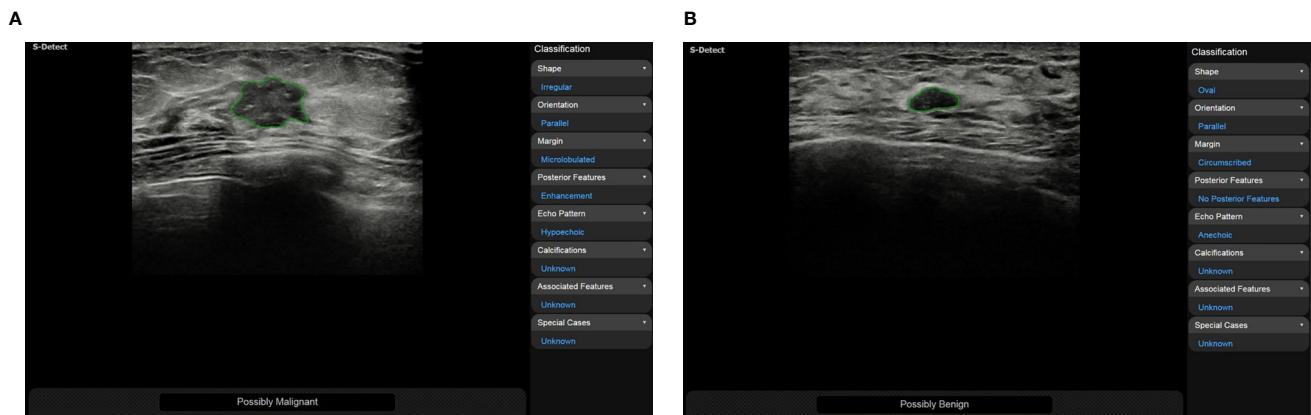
(A) A 50-year-old woman was diagnosed with invasive cancer, and the results of CAD (S-Detect, Samsung RS80A ultrasound system) were “possibly malignant”; (B) A 48-year-old woman was diagnosed with adenosis, and the results of CAD were “possibly benign”.
